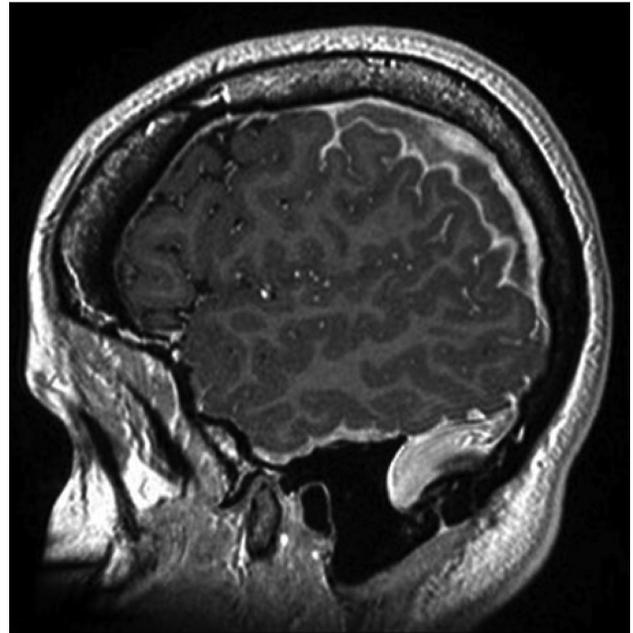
Magnetic resonance imaging of the skull, T1-weighted, sagittal plane, 14 days after spinal anesthesia, demonstrating left subacute subdural hematoma.
